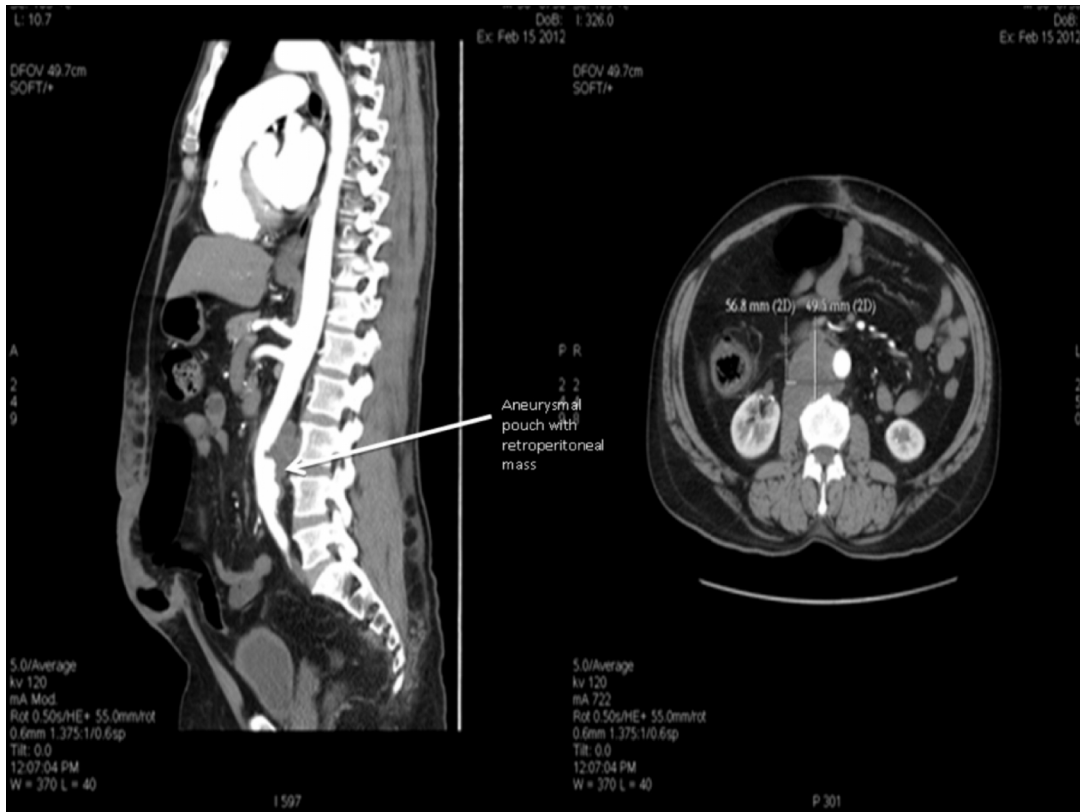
CT revealing aneurysm at infra renal segment of aorta below the level of renal arteries along with retroperitoneal mass
